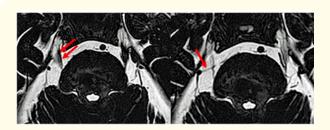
MRI (Constructive interference in steady state).
